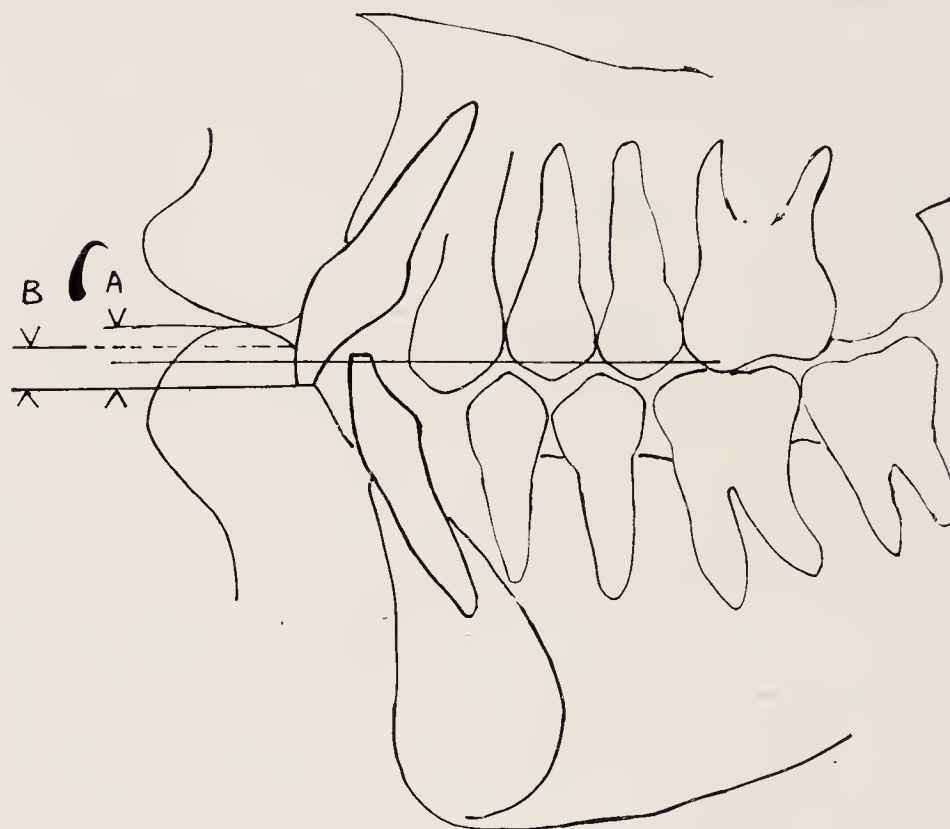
Tracings of X-ray showing: A, Total height of lip above incisal tip of upper central incisors; B, Height of lip in contact with central incisors.
